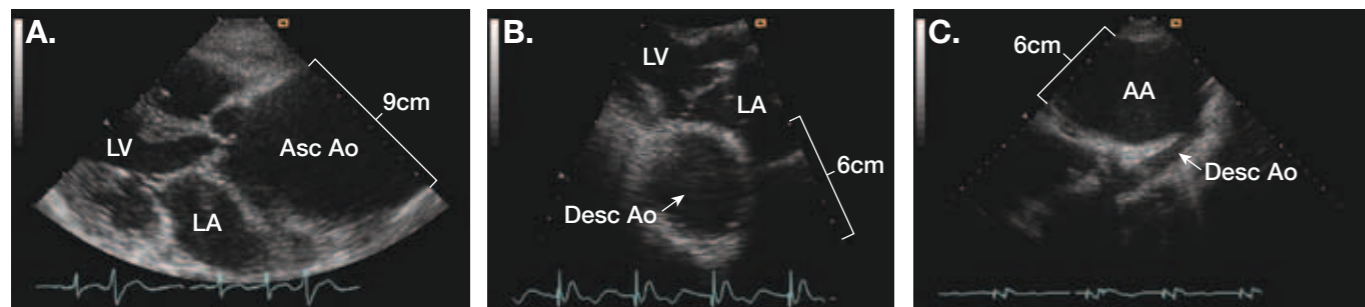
These images show three aortic aneurysm sites from three different patients. A: From the parasternal long axis view an aneurysm of the ascending aorta (Asc Ao) is shown; observe that the ascending aorta is approximately 9 cm wide with effacement of the sinotubular junction. B: From this zoomed and slightly off-axis parasternal long axis view an aneurysm of the descending aorta (Desc Ao) is shown; the maximum diameter of this aneurysm was measured at 5.6 cm. C: From the suprasternal view an aneurysm of the aortic arch (AA) is shown; observe that the maximum arch diameter is more than 6 cm. LA = left atrium; LV = left ventricle.
